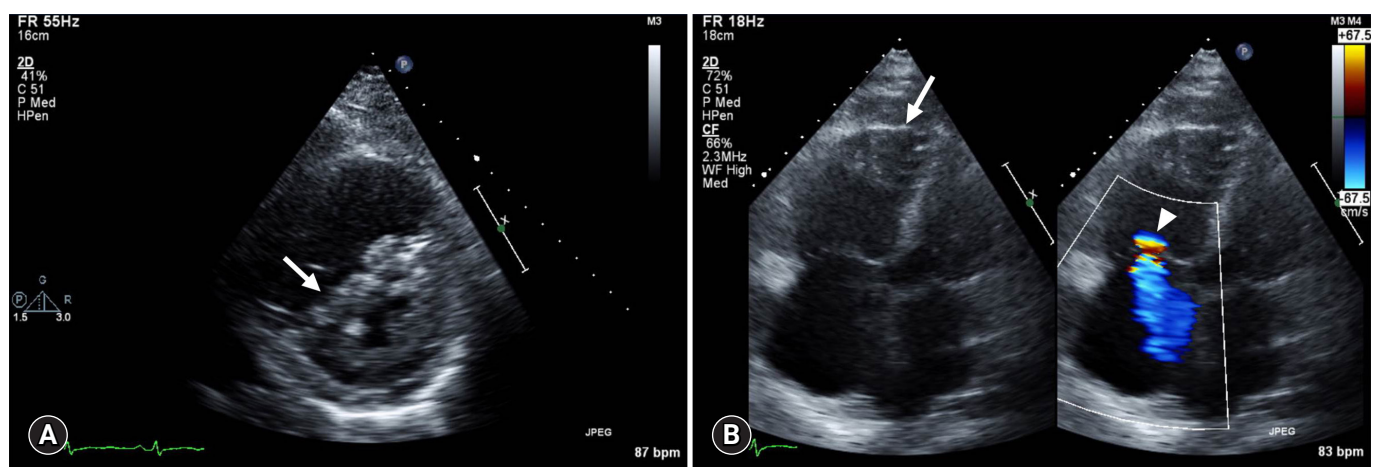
Transthoracic echocardiography. (A) Parasternal short-axis view shows LV systolic septal flattening (arrow) with RV enlargement. (B) Apical 4 chamber view with color Doppler of the tricuspid valve shows RV enlargement (arrow) and moderate tricuspid regurgitation (arrowhead). LV, left ventricle; RV, right ventricle.
